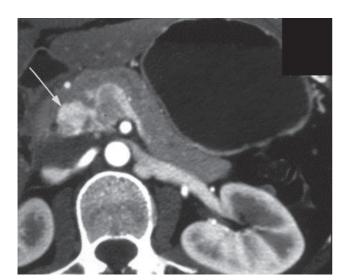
Post IV contrast CT scan reveals an enhancing neuroendocrine tumor (arrow) of the pancreatic head in a 36-year-old female with Von Hippel-Lindau syndrome.
